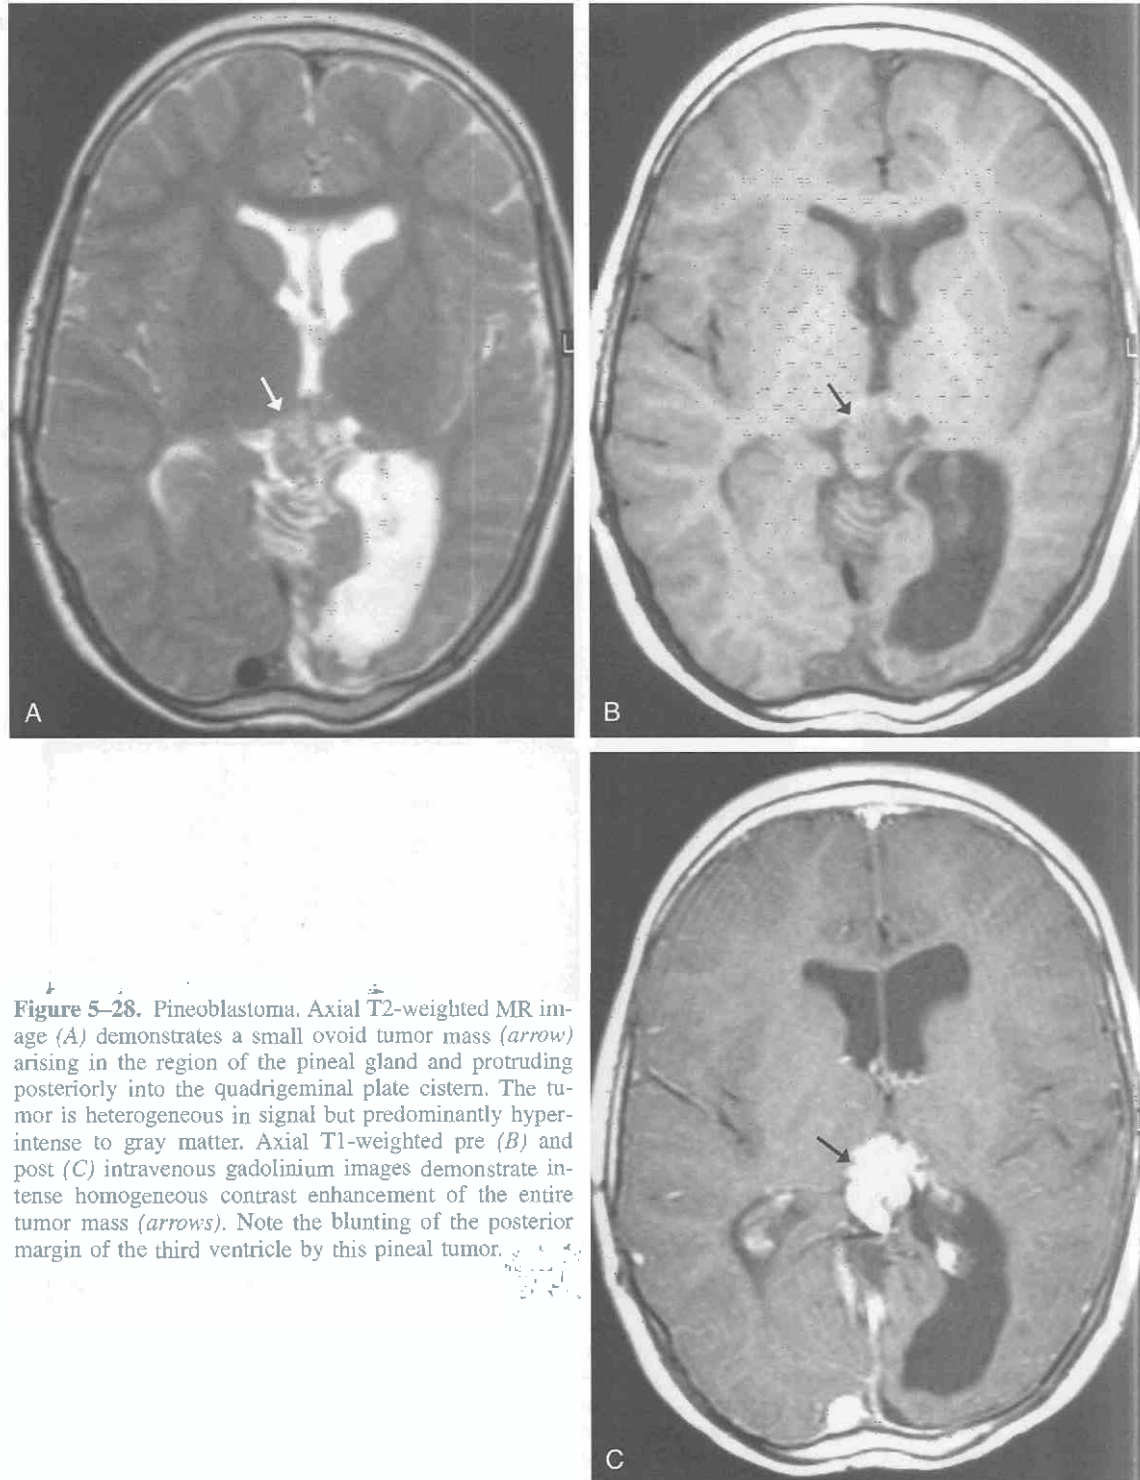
Pineoblastoma. Axial T2-weighted MR image (A) demonstrates a small ovoid tumor mass (arrow) arising in the region of the pineal gland and protruding posteriorly into the quadrigeminal plate cistern. The tumor is heterogeneous in signal but predominantly hyperintense to gray matter. Axial T1-weighted pre (B) and post (C) intravenous gadolinium images demonstrate intense homogeneous contrast enhancement of the entire tumor mass (arrows). Note the blunting of the posterior margin of the third ventricle by this pineal tumor.
